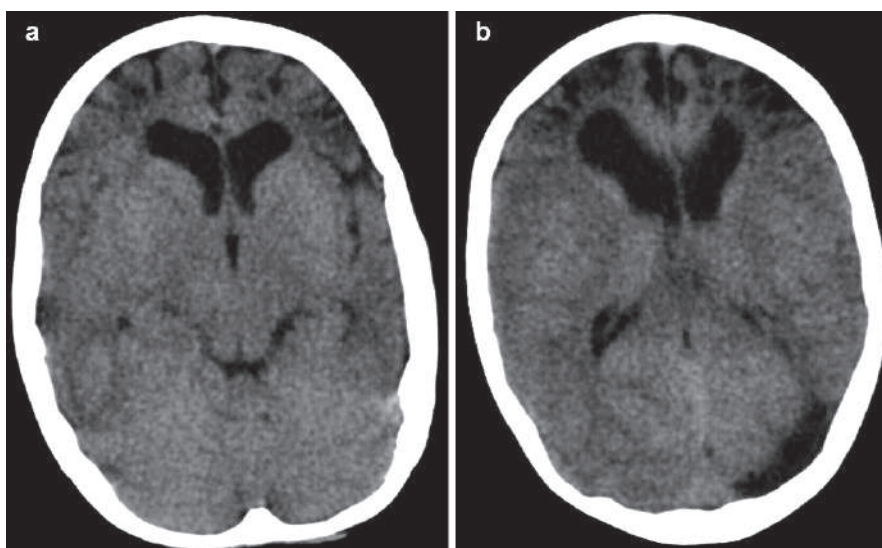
Axial sequential brain CT images of a patient with frontotemporal dementia (FTD) show bilateral frontal lobes atrophy with dilatation of the anterior horns of the lateral ventricles
